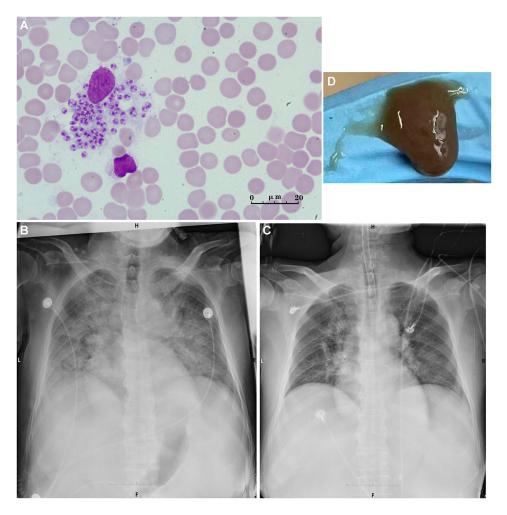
Figure I Examination of the case of visceral leishmaniasis: (A) Leishmania amastigotes were examined by BMA. (Wright-Giemsa, 1000×). (B) Chest X-ray disclosed bilateral pulmonary edema. (C) A recheck of chest X-ray showed significant resolution of pulmonary edema. (D) Brown sputum was aspirated from the patient's endotracheal tube.
